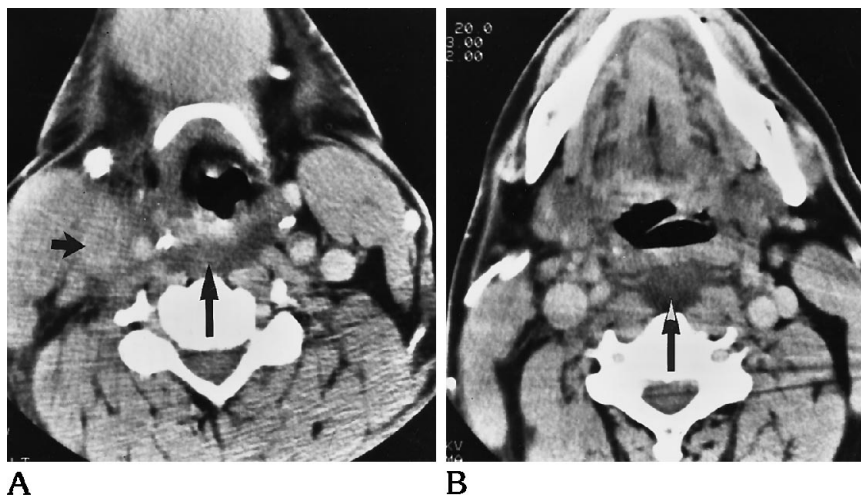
49-year-old man with fever and neck pain. Axial CT scan (A) at the level of the hyoid displays right internal jugular vein thrombosis (*short arrow*) with edema in the adjacent carotid space. A low-density mass-like appearance is appreciated in the retropharyngeal space (*long arrow*) at this level and higher at the level of the tip of the epiglottis in B.
